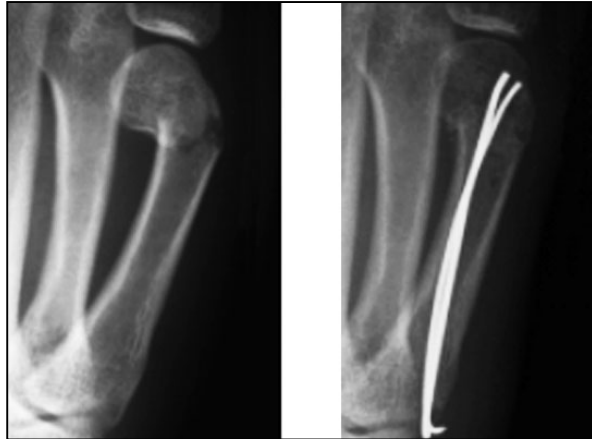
XRAY with 2 k wire's showing angular correction immediately after operation
